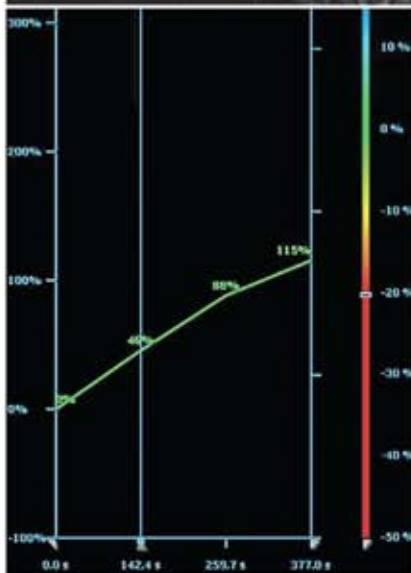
High-grade DCIS appearing as a nodular-enhancing lesion on contrast-enhanced T1-w images. Enhancement kinetics (Type 1) was more in keeping with a benign lesion. An increase in size of the lesion was noted compared to a previous MRI scan, which prompted biopsy.
